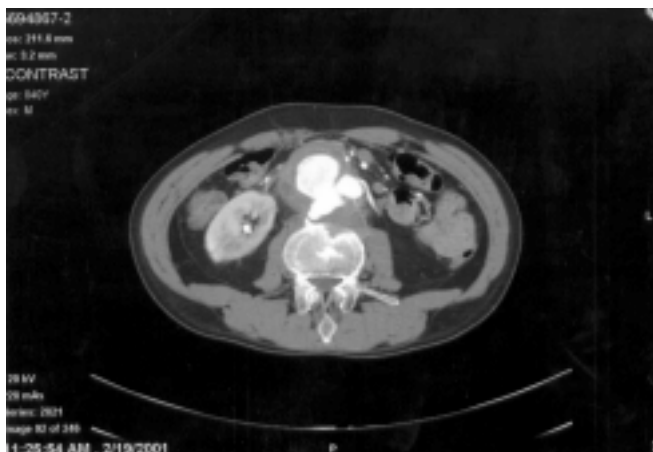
An axial slice from CT angiography showing the abdominal aorta with a large (5.5 cm) irregular aneurysm extending from the anterior abdominal wall to the vertebral column. The inferior mesenteric artery (IMA) is patent. There is erosion of the vertebral body.
